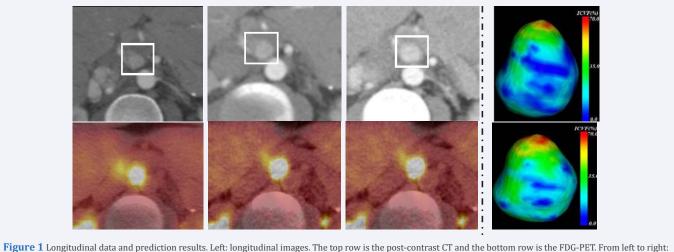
Longitudinal data and prediction results. Left: longitudinal images. The top row is the post-contrast CT and the bottom row is the FDG-PET. From left to right baseline, the 1<sup>st</sup> follow up, the 2<sup>nd</sup> follow up. Right: the top image is the reference ICVF map and the bottom is the predicted ICVF map.
